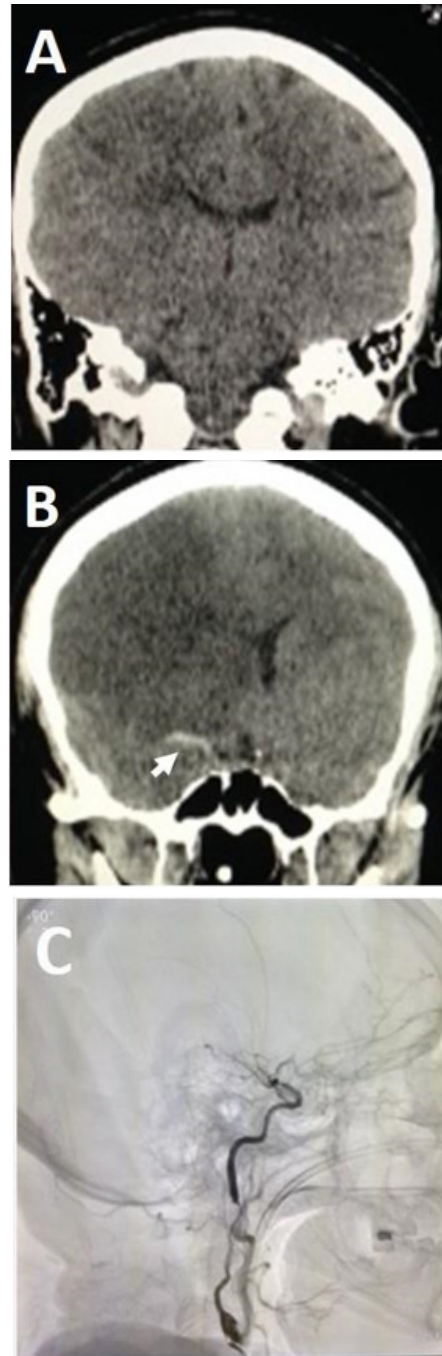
A. A head computed tomography scan showed slight edema in the right cerebral parenchyma without deviation of the midline structures. B. Twenty-four hours later, the patient became drowsy, and a new CT scan of the skull showed considerable edema (hypodensity) in the right cerebral hemisphere involving the middle cerebral artery (MCA) territory. See the hyperdense MCA sign or Gács sign, representing thromboembolic material within the arterial lumen (arrow). C. Arteriography of the neck and head vessels showing a dissection of the right carotid artery and occlusion of the right middle cerebral artery in the M1 segment.
